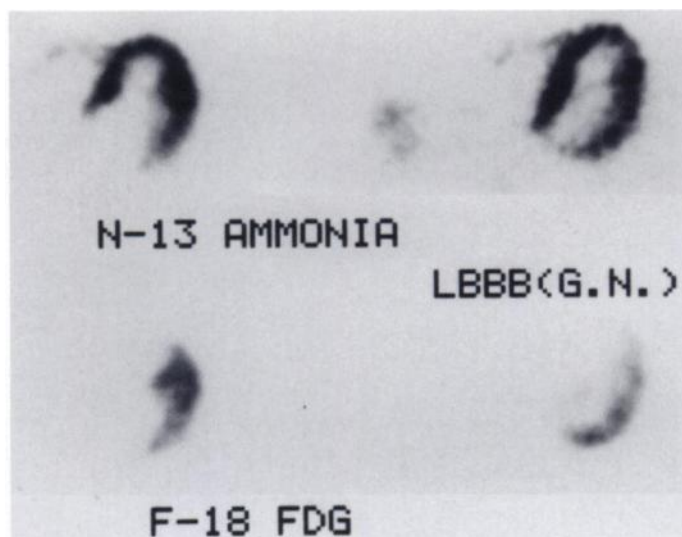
Two representative transverse slices of ^{13}N -ammonia perfusion and ^{18}F -FDG images of a patient with LBBB. While myocardial perfusion is normal, FDG uptake is significantly decreased in septal region, indicating a decrease in glucose utilization.
